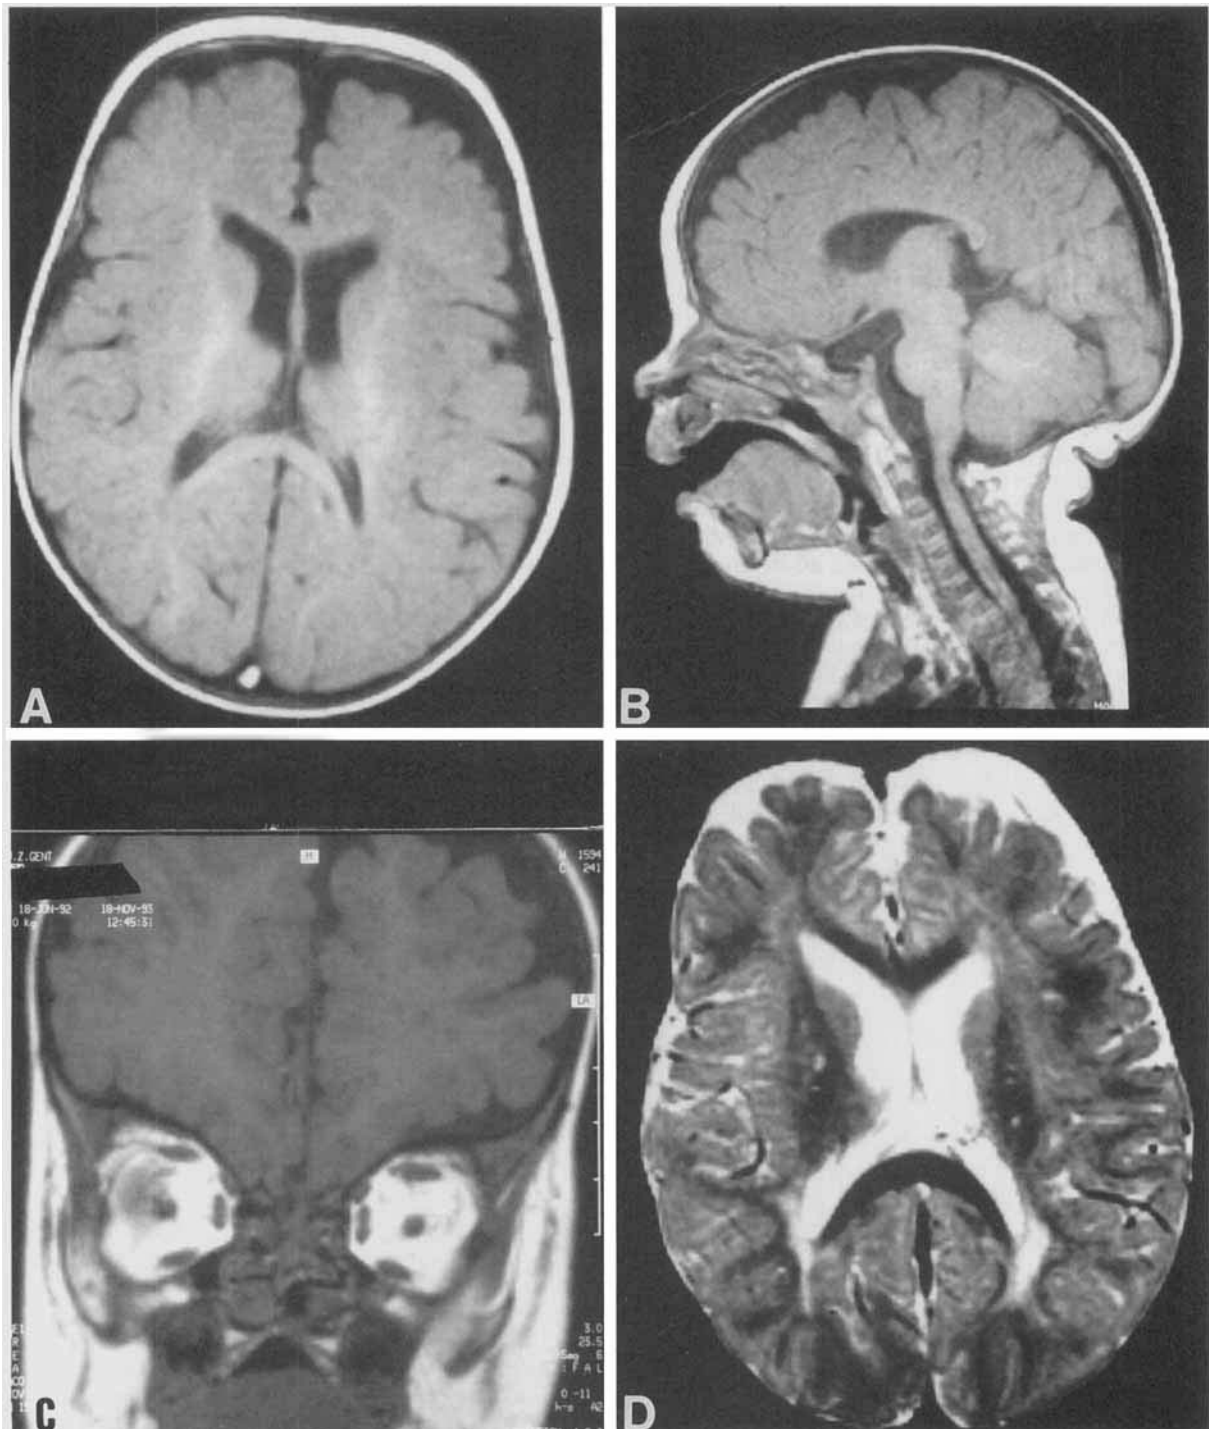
MRI-scan (T_1 weighted) of brain at age six months. A: Enlarged frontal and temporoparietal subarachnoid spaces; mild enlargement of frontal horns of lateral ventricles. B: Mild communicating hydrocephaly also apparent on lateral view. MRI scan at 17 months. C: Retro-orbital part of extrinsic eye muscles visible; lateral rectus muscles partly hidden within shadow of orbital wall. D: T_2 -weighted image: stable enlargement of subarachnoid and intraventricular spaces; some white matter alteration around occipital horns.
